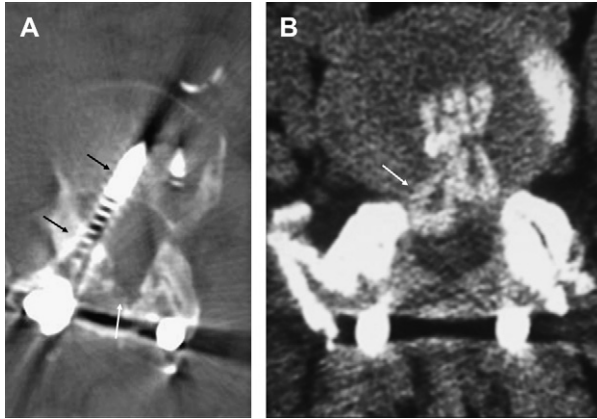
Postoperative spine. (A) Malpositioned interpedicular screw. Axial CT—right side screw encroaching on the lateral recess of spinal canal (*dark arrows*). Note laminectomy defect (*white arrow*). (B) Displaced bone graft cage. Axial CT with intravenous contrast—focal compression of thecal sac by retropulsed cage (*arrow*).
